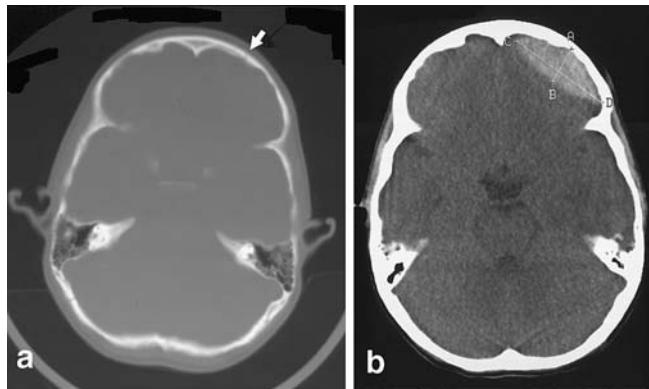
a Pre-operative head CT scan (bone window) demonstrating a linear left frontal fracture secondary to a golf ball impact; b pre-operative head CT scan (parenchymal window) on the same patient demonstrating a left frontal epidural hematoma
